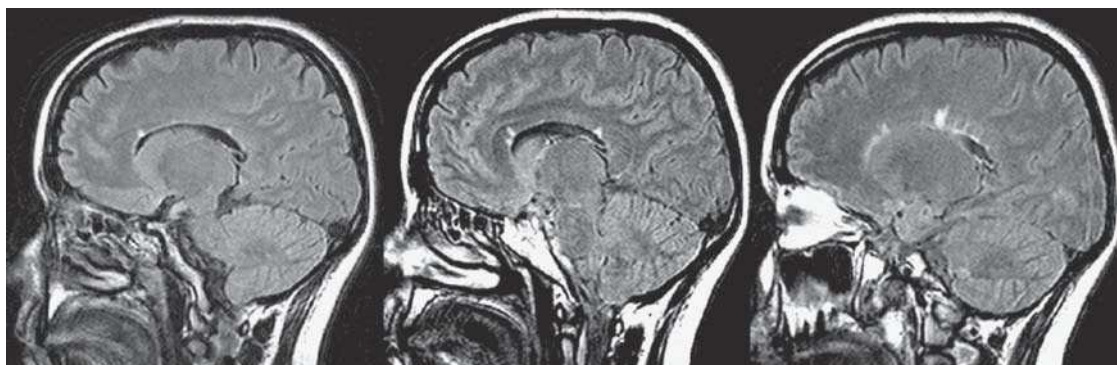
Brain magnetic resonance imaging. Sagittal fast-FLAIR sequence in a patient with a first clinical event of possible demyelinating origin. Periventricular hyperintense focal lesions can be observed, as well as in the subependymal area of the corpus callosum.
